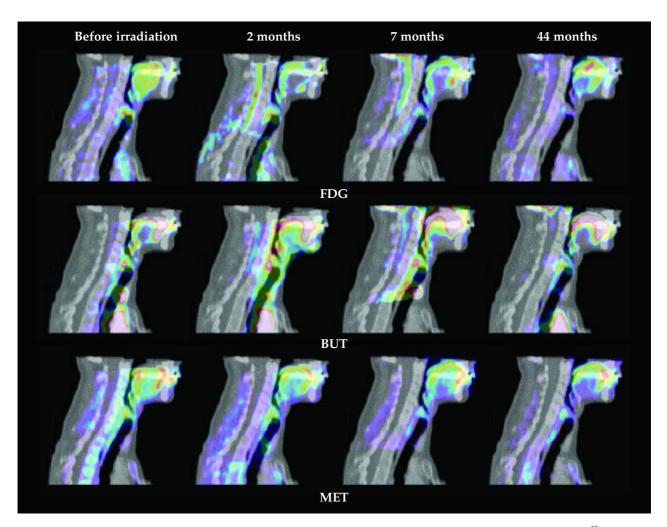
Fused CT-PET images of the median sagittal section of the head and neck region using FDG (upper panel), [¹⁵O]butanol (middle panel) and [¹¹C]methionine (lower panel), as tracers before irradiation and during the clinical course (2, 7, and 44 months following irradiation). The consecutive images display SUVs on an identical scale
